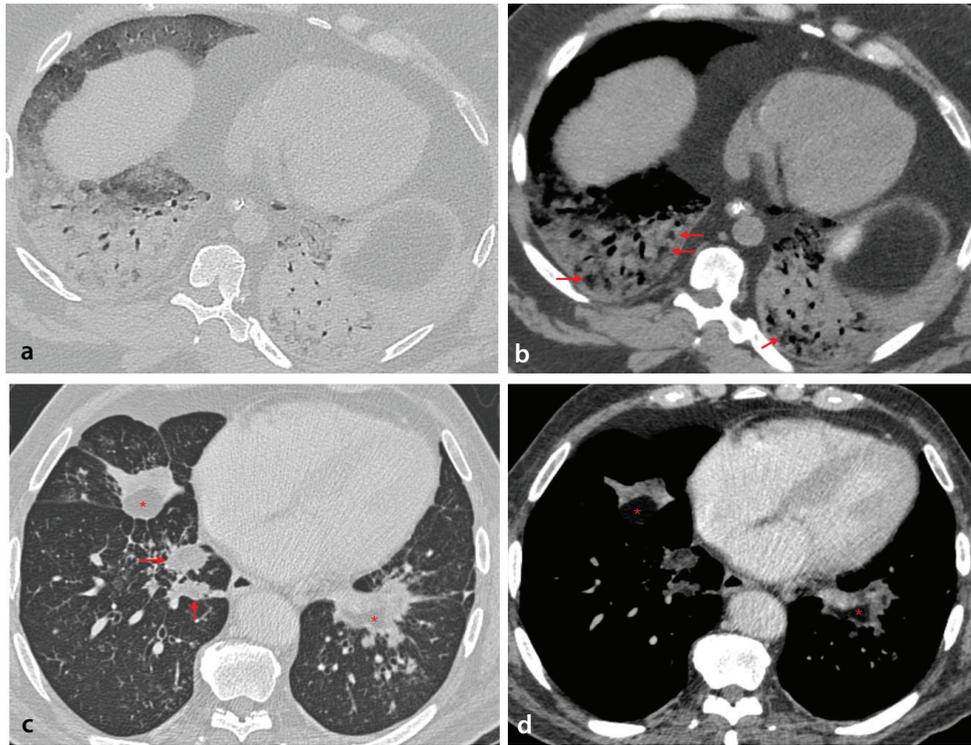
Lipoid pneumonia patterns on chest computed tomography (CT). Axial CT images (a, b) show bilateral lower-lobe consolidations with areas of negative attenuation (arrows) in a patient with acute respiratory failure, consistent with endogenous lipoid pneumonia. Axial CT images (c, d) demonstrate mixed-attenuation masses and nodules containing fat-density areas (asterisks) in a patient with chronic constipation and a history of oral oil-based laxative use, consistent with exogenous lipoid pneumonia due to aspiration.
